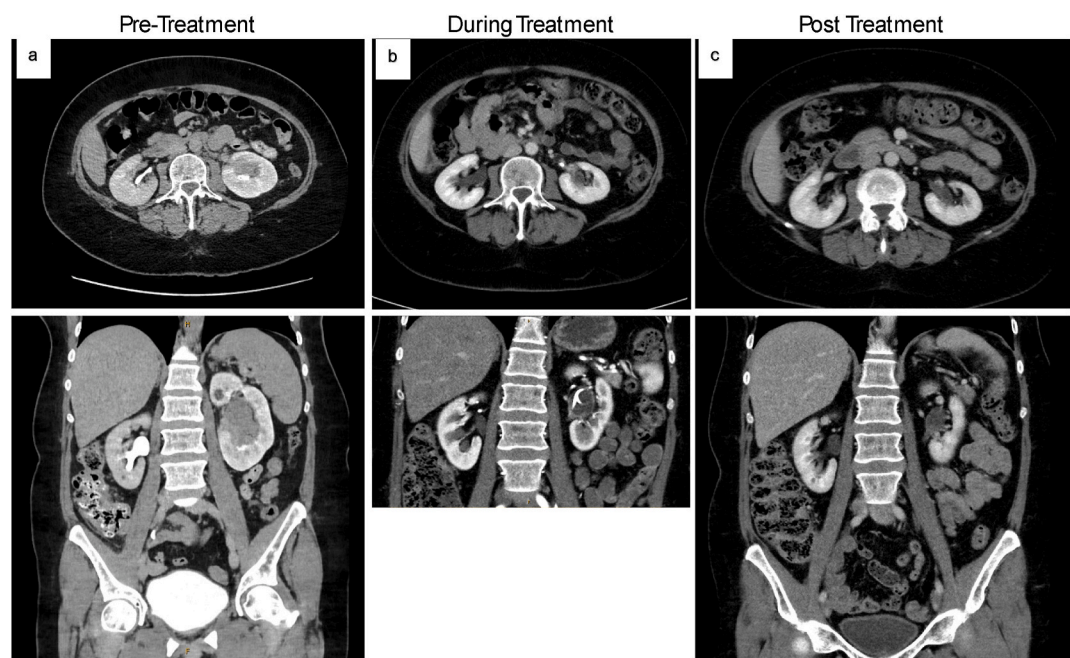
CT-AP with delayed phase demonstrating (a) significant left hydronephrosis, delayed nephrogram, and renal pelvis ureteric thickening extending to the PUJ pre-treatment, (b) moderate resolution of renal pelvis thickening with stent in situ during treatment, and (c) complete resolution of renal pelvis/PUJ thickening post-treatment. Top row = axial views, bottom row = coronal views.
